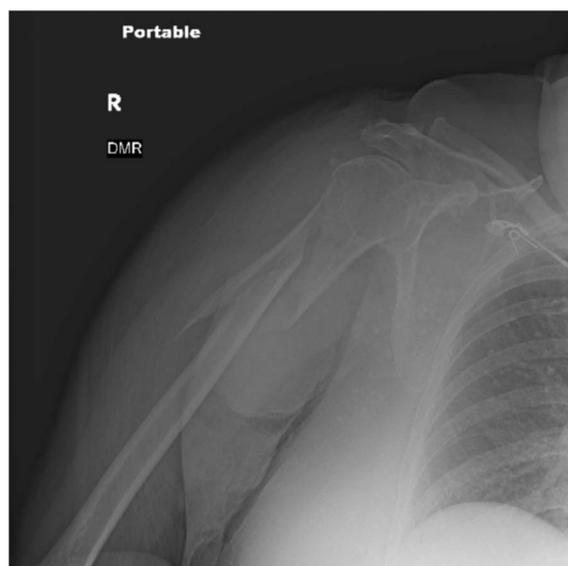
Radiograph from the emergency department that demonstrate a spiral proximal humerus and shaft fracture with significant displacement in a morbidly obese patient.
